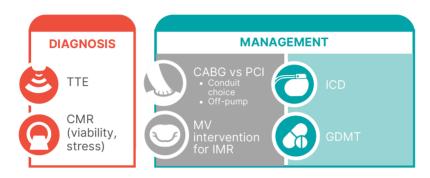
Considerations for the Management of CAD with reduced LVEF. CABG: Coronary artery bypass grafting; CMR: cardiac magneticresonance; GDMT: guideline-directed medical therapy; ICD: implantable cardioverter-defibrillator; IMR: ischemic mitral regurgitation; MV: mitral valve; TTE: transthoracic echocardiography.
